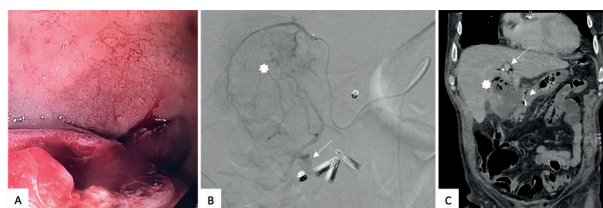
Images of Case 1. – A. Endoscopic view of a submucosal mass in the duodenal bulb with active oozing (Forrest Ib). B. An arteriographic image demonstrating a liver tumor with vascular atypia's (asterisk) and extravasation of contrast medium in the duodenum (arrow) C. A coronal abdominal CT-scan image showing the hepatic mass invading the duodenum. Note the presence of enteric fistula (asterisk), haemostatic clips (arrow) and microcoils (arrowhead).
